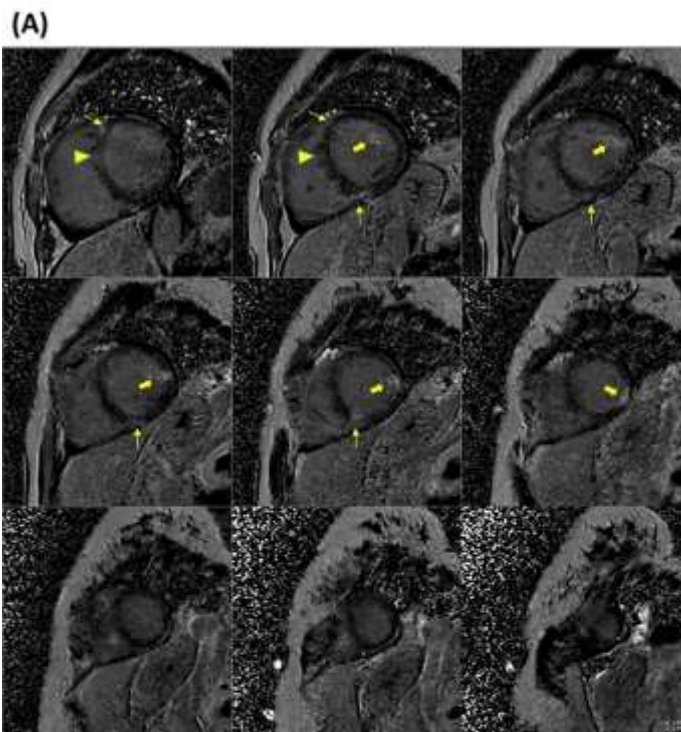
(A) Cardiac MRI: late gadolinium enhancement imaging (PSIR) in short axis stack. There is patchy myocardial fibrosis in the anterolateral papillary muscle and a small portion of the mid lateral wall (thick arrows). There is mid-wall fibrosis in the basal anteroseptal segment (arrow head). Additionally, there is fibrosis at both anterior and inferior right ventricular insertion sites (thin arrows). The pattern of myocardial fibrosis is compatible with non-ischemic cardiomyopathy. (B) Coronary angiography: (left) RAO cranial of LCA, (middle) LAO caudal view of LCA, and (right) LAO view of RCA. There was no significant coronary artery disease.
